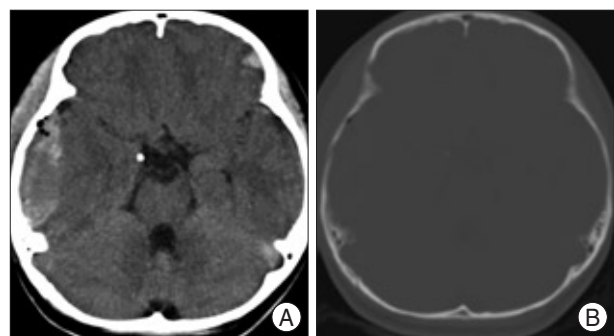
Computed tomography scans without contrast medium (A) and with bone setting (B) obtained 4 hours after injury reveals an acute epidural hematoma of heterogeneous density with an overlying fracture in the right temporal region and acute small hemorrhagic contusion in the left frontal region. Air bubbles in the acute epidural hematoma are noted.
